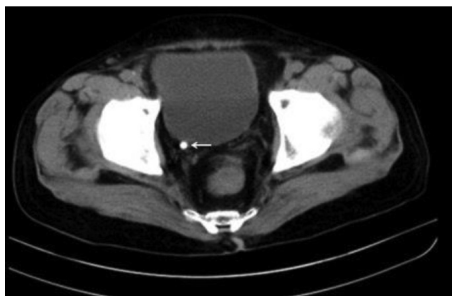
Post-operative abdominal CT scan of the abdomen. Arrow showing right distal ureteral stone
